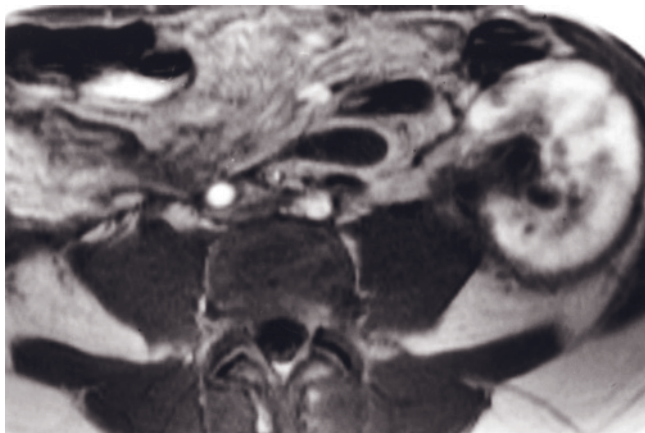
Acute focal pyelonephritis in a renal transplant. T1-weighted immediate (a) and 90-s fat-suppressed (b) postgadolinium SGE images demonstrate a focal region anteriorly in the transplant kidney that shows a striated nephrogram appearance on the capillary-phase image (arrows, a) that resolves on the interstitial-phase image (b). This appearance is consistent with acute focal pyelonephritis without abscess formation.
